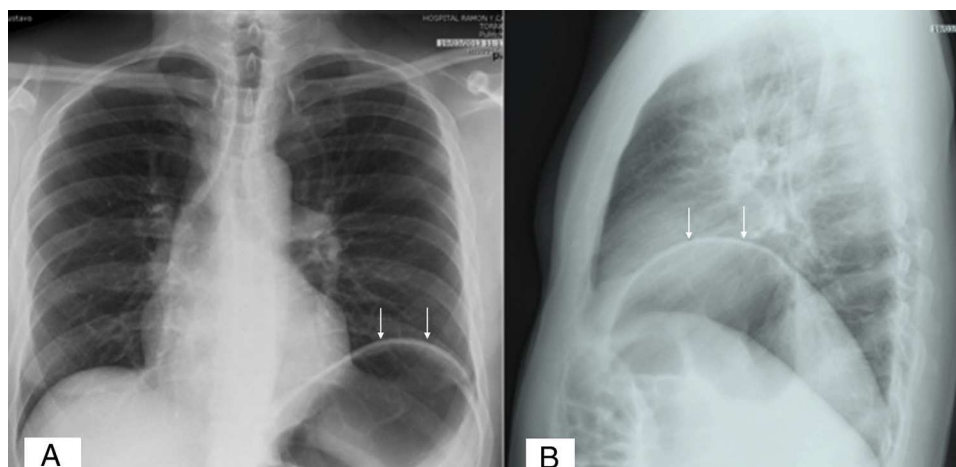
Posteroanterior (A) and lateral (B) chest X-ray showing left hemidiaphragm elevation (arrows).
